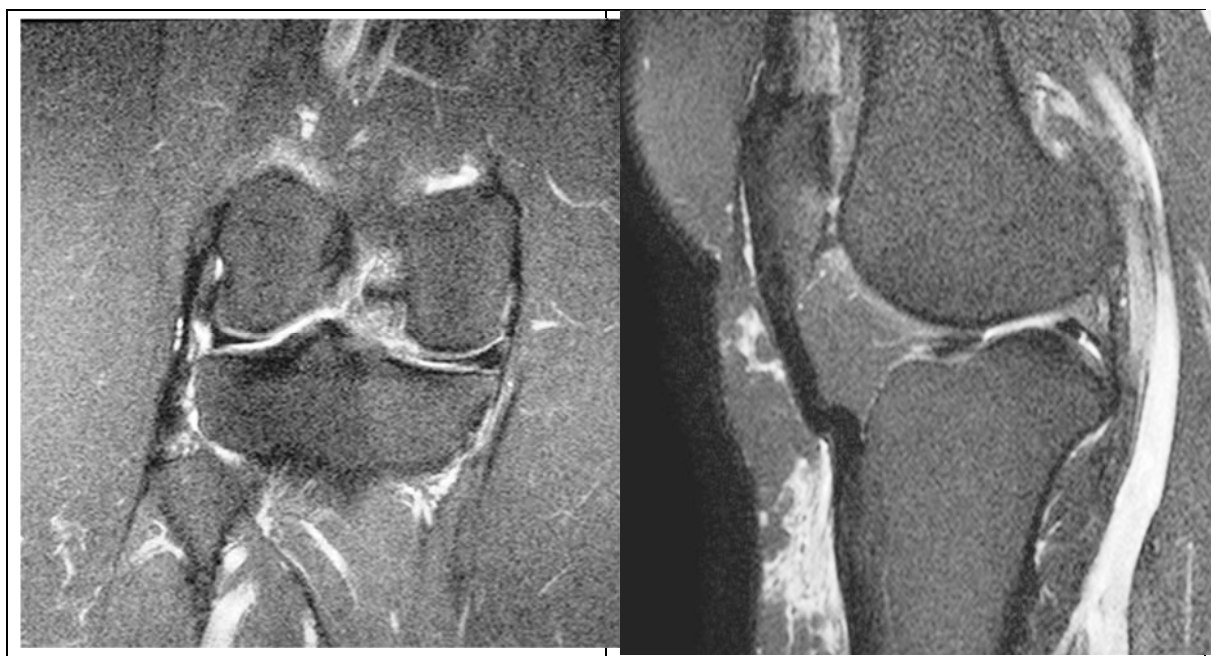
Suboptimal but still readable coronal (a) and sagittal (b) intermediate-weighted fat-suppressed MRI of the knee with low signal to noise ratio in an obese subject. In this
